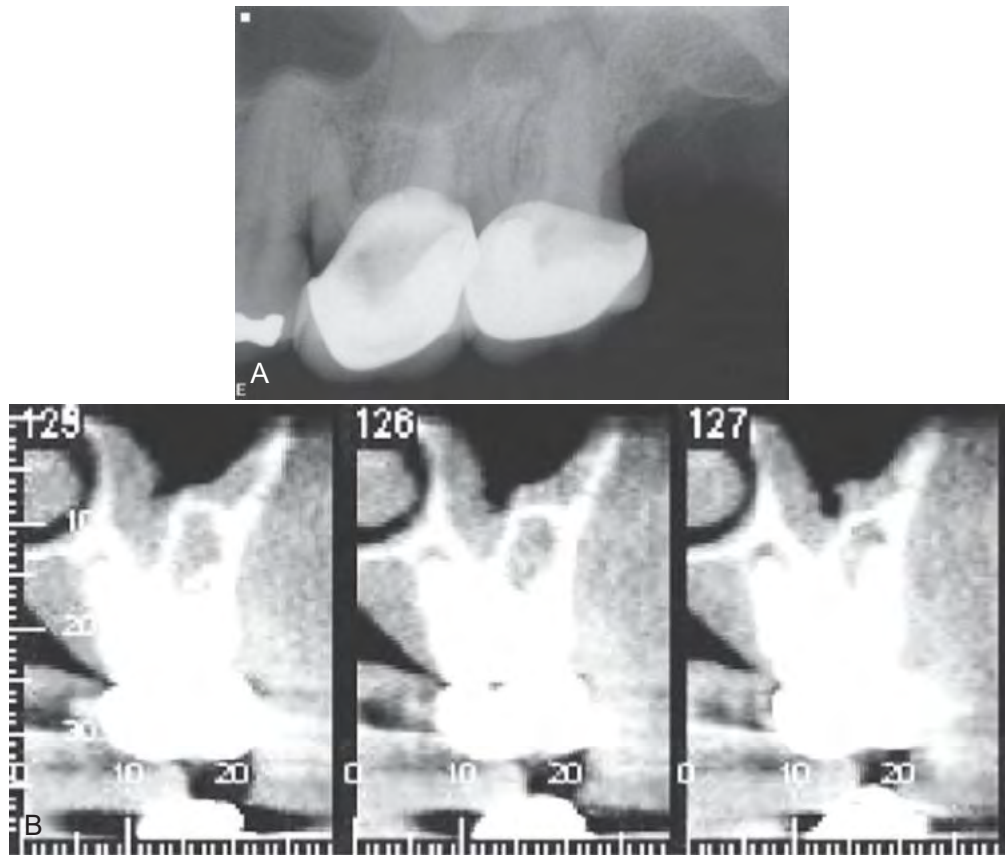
A, This standard two-dimensional radiographic image reveals recurrent caries under the mesial margin of the maxillary first molar. However, the patient localized pain to mastication on the maxillary second molar. B, Cone-beam volumetric tomography revealed an apical radiolucency associated with the maxillary second molar. The bone loss was obscured on the two-dimensional radiograph by the maxillary sinus, zygoma, and cortical bone.
